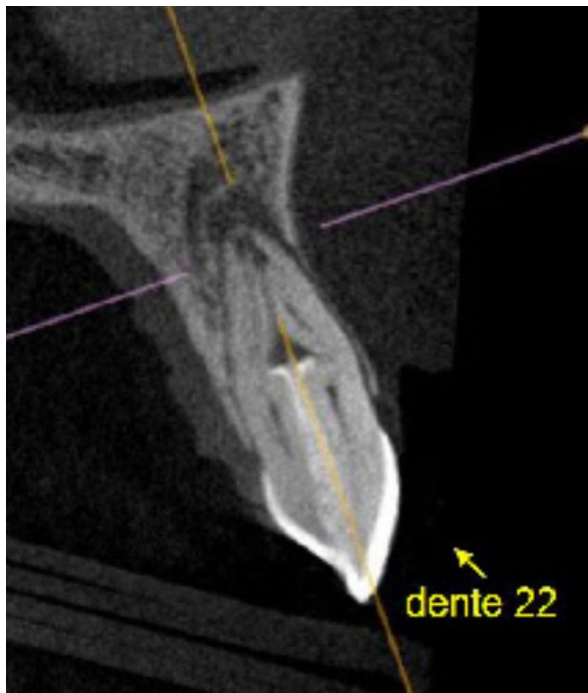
Initial cone beam computed tomography (CBCT)
